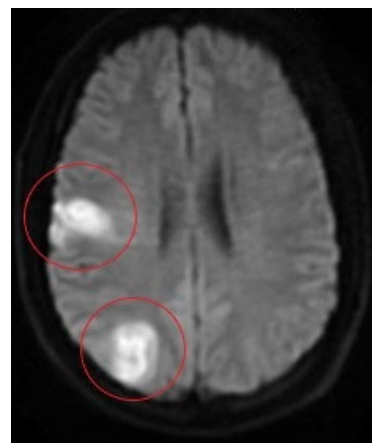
Magnetic resonance imaging showed multifocal regions of infarction (red circles) within the right middle cerebral artery territory, suggestive of a proximal embolic source.
